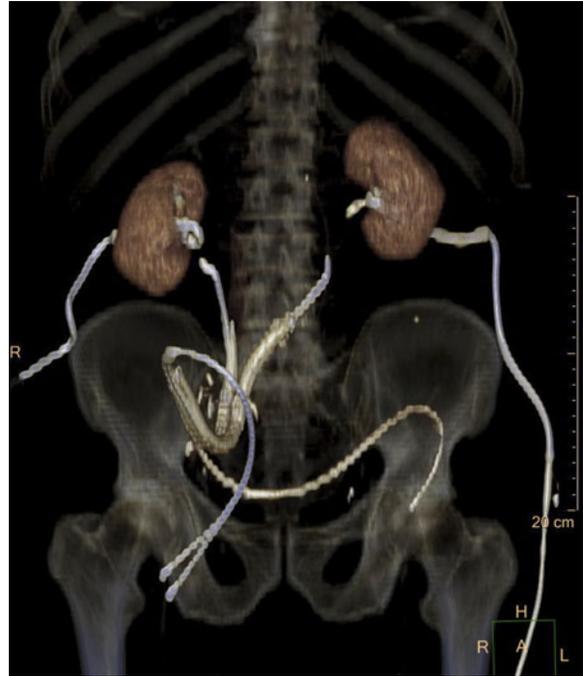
Volume rendered image from a CT IVP showing the stents *in situ* as well as bilateral nephrostomies and bilateral occlusion balloons within the stents.
